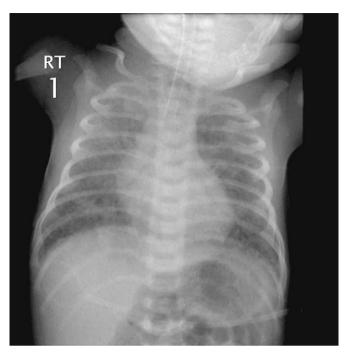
Chest X-ray of a ventilated infant with meconium aspiration syndrome showing typical appearances of hyperinflation and patchy interstitial shadowing.
